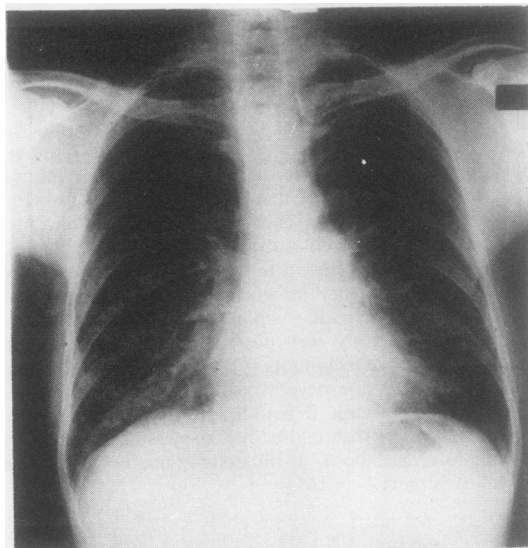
Chest radiograph showing bilateral diffuse alveolar pattern of infiltrate.
